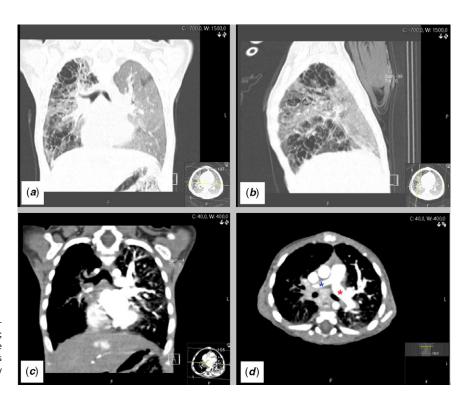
(a + b) Chest CT angiogram: coronal (a) and sagittal (b) views showing cystic-like lesions in the right lung; (c) coronal view showing reduced vascular markings in the right lung; (d) axial view showing asymmetrical branches of the pulmonary artery. "Blue asterisk" – right pulmonary artery; "Red asterisk" – left pulmonary artery.
